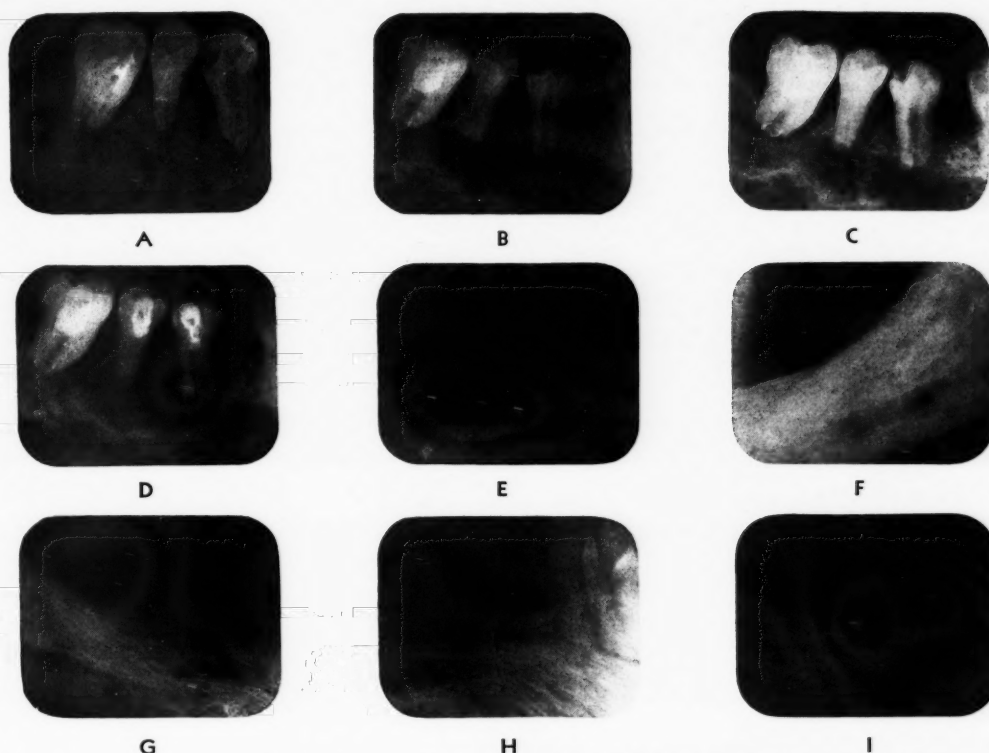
Roentgenographic representation of the course of the disease.
